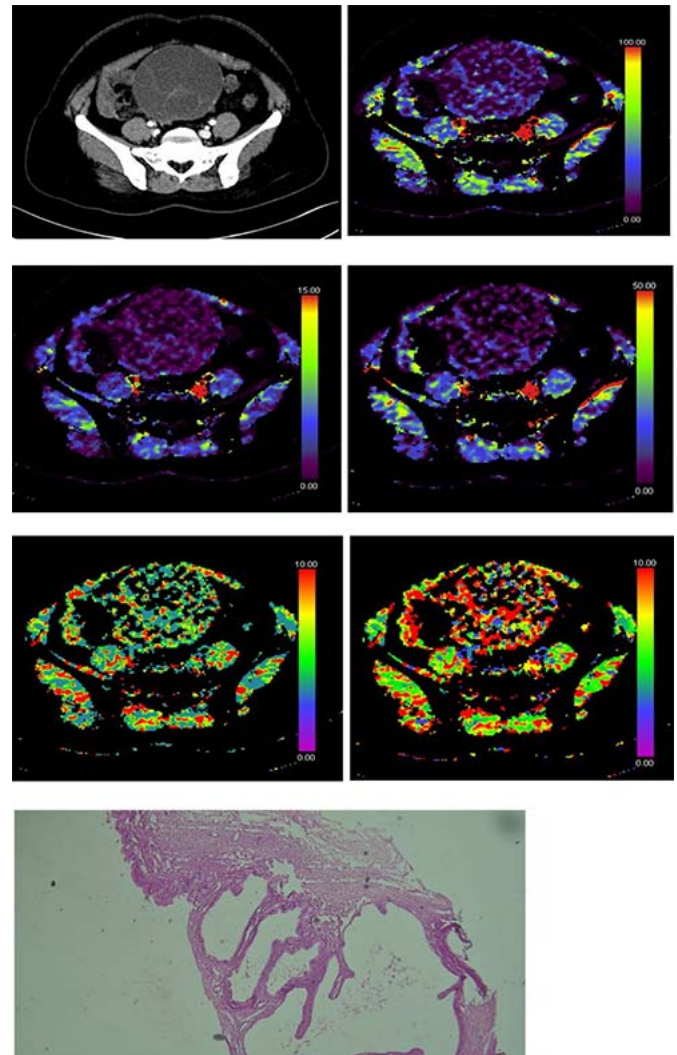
CT perfusion of left mucinous cystadenoma a: PCT image showing left ovarian multiseptated cystic lesion with septal enhancement b: BF 67.67 ml/100gm/min c: BV 3.48 ml/100gm d: FED 9.2 ml/100gm/min. e: MTT 3.19 sec f: T max 3.68-sec g: HE 10× showing mucinous cystadenoma with mucinous epithelial lining and fibro collagenous stroma.
